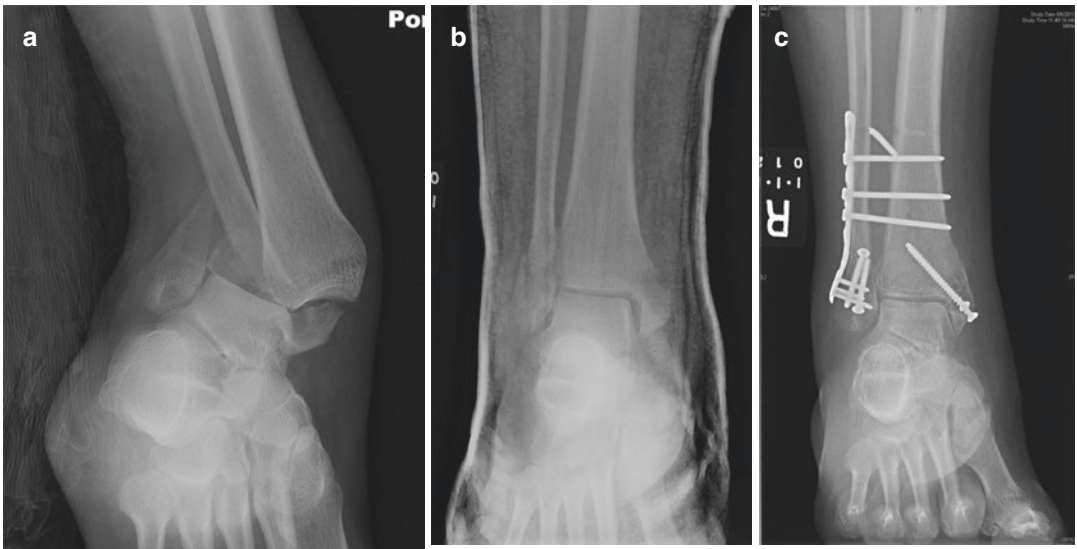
Unstable ankle fracture following a low energy injury in an insensate diabetic patient (a). Radiographs following closed reduction reveal the low energy nature of the injury (b). Radiographs following open reduction internal fixation with augmented internal fixation (c). The lateral plate is used as a washer for the syndesmotomic screws that are used for augmented internal fixation
